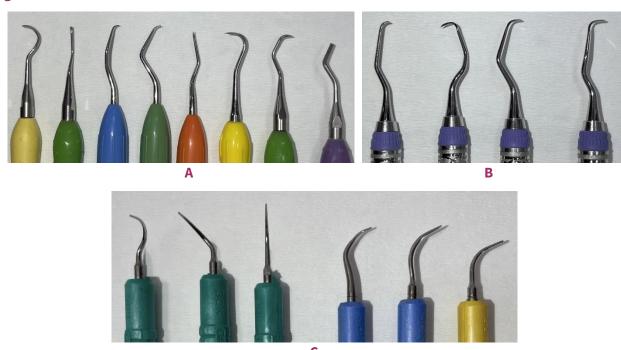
Image A shows a variety of instruments suitable for supragingival PMPR. Image B shows site-specific Gracey curettes for subgingival PMPR. Image C shows various ultrasonic scaler inserts: green tips for removal of calculus from root surfaces or where minimal deposits are present; blue tips for supragingival PMPR; yellow tips (with appropriate plastic covering) for use around dental implants.
